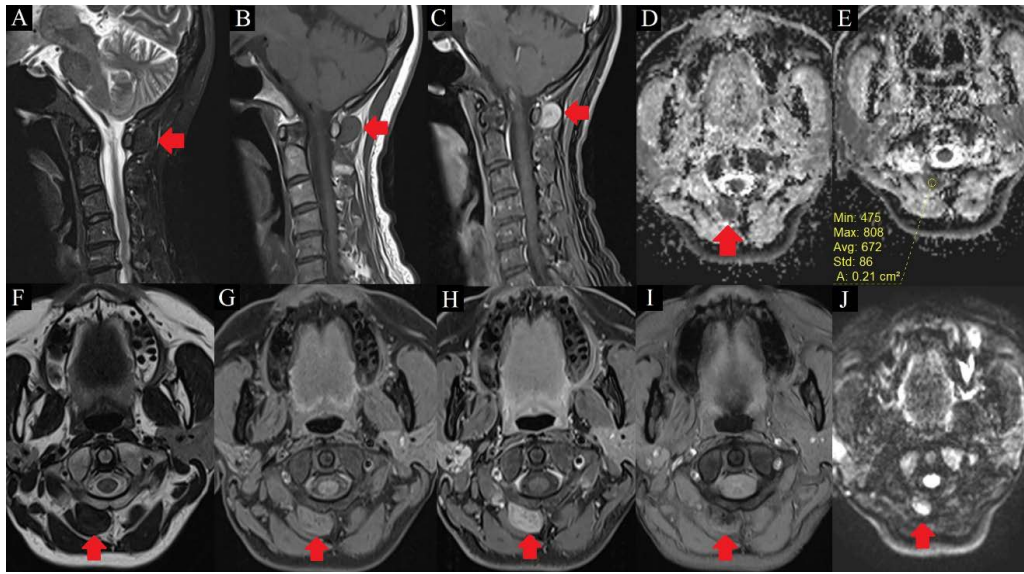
MRI images of a 54 year-old lady with tenosynovial giant cell tumor at the upper cervical spine, likely arising from the posterior atlantoaxial membrane.
